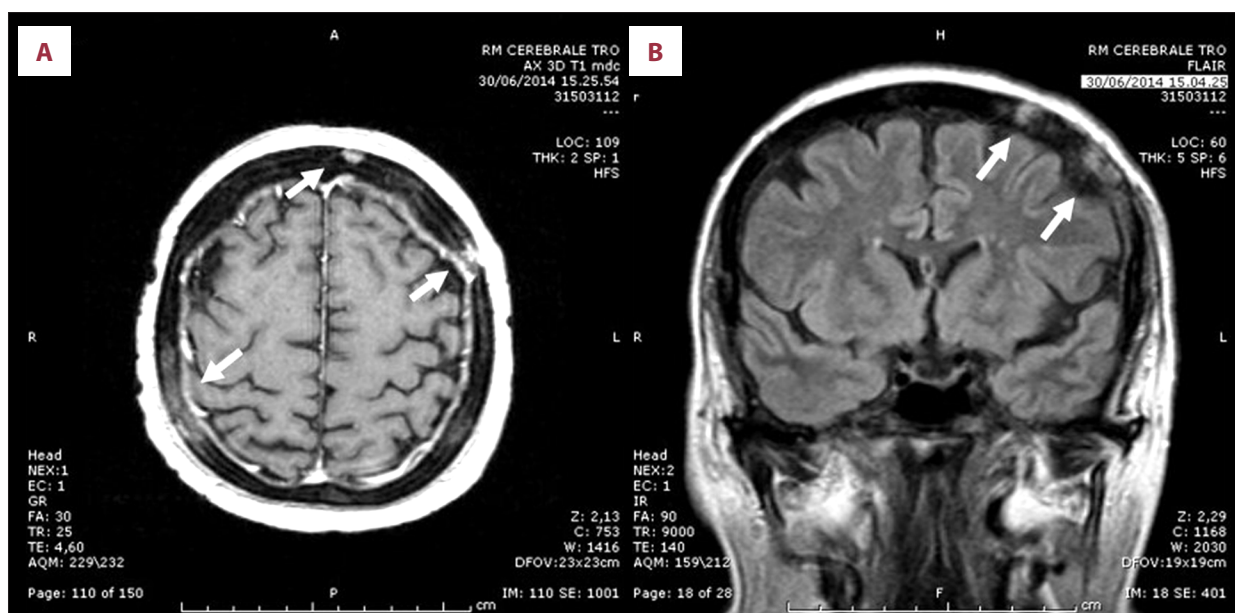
(A) The contrast-enhanced T1-weighted MRI shows multiple and diffuse bone metastatic lesions that infiltrate dural tissue into the subarachnoid space. Thickened and irregular enhancement with surrounding edema is seen along frontal, left, and right parietal lobes. (B) Flair (fluid attenuated inversion-recovery) shows the erosive changes of the cortical margins of the cranial bone with masses involving the subarachnoid space.
